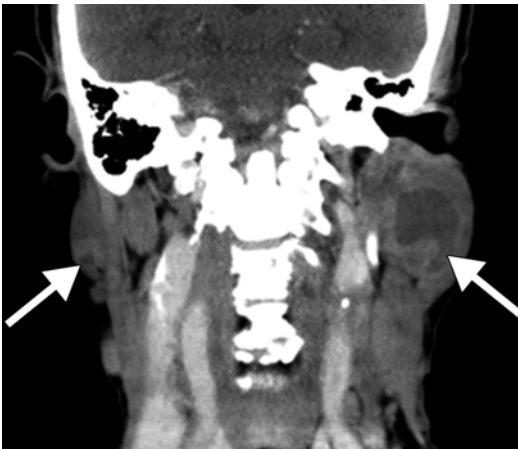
Benign lymphoepithelial lesions in a patient with HIV. The coronal CT image shows cystic lesions in the bilateral parotid glands (*arrows*). The lesion on the left side contains a solid nodule
